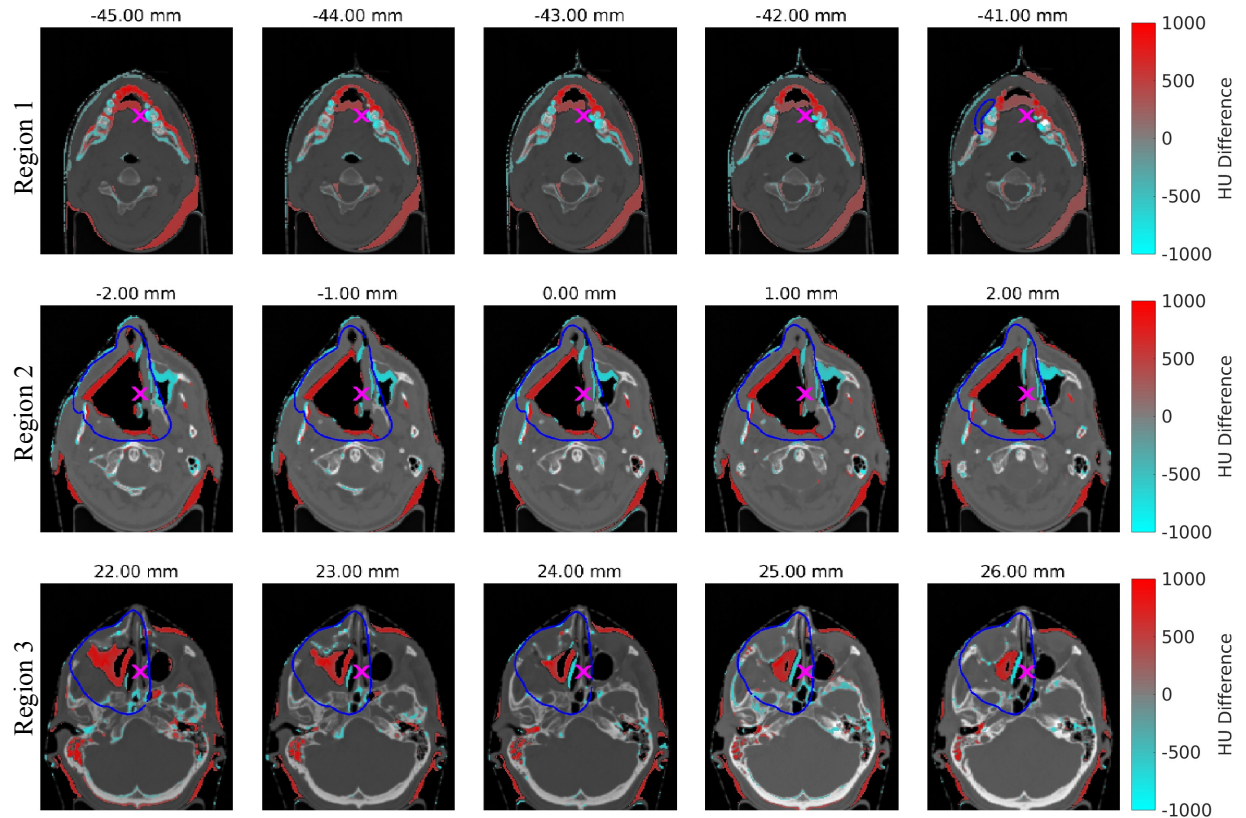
Anatomical changes between the planning and follow-up CT, taken 46 days apart, based on HU differences. Each row contains 5 axial CT images spaced 1 mm apart, covering a total of 5 mm of patient anatomy and representing an anatomical region where changes occurred. All changes are superimposed on the planning CT. Three regions are shown in total, and the slice positions, relative to the isocenter, are indicated above each image.
